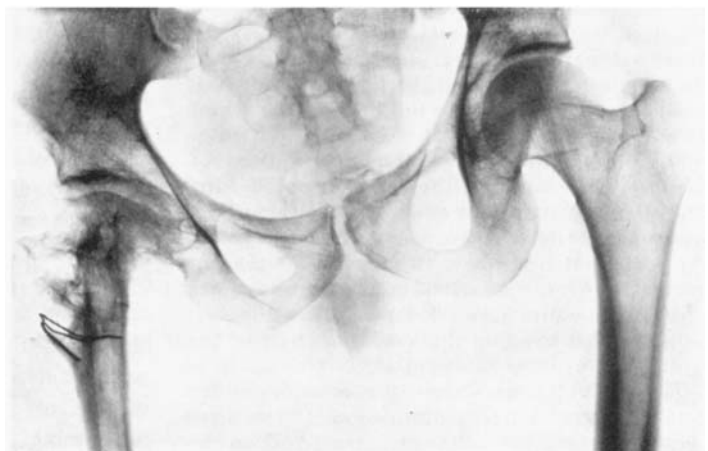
c. Radiograph taken 18 years after Brackett's operation. The patient, now 36 years old, is a labourer. The hip is tender on exertion and has become stiffer, but Trendelenburg's sign is negative. The femoral head is flattened in shape and incipient, slight osteoarthritis is visible.
